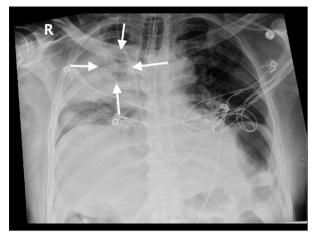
Chest X-ray on day 3 of admission. Arrows point to persistent right upper lobe consolidation.
